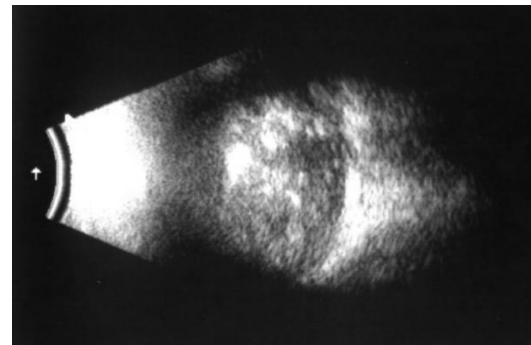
B-scan Ultrasound Image of Retinoblastoma. Irregular solid lesion within the vitreous, with heterogeneous internal echoes and detectable punctate hyperechoic foci.
